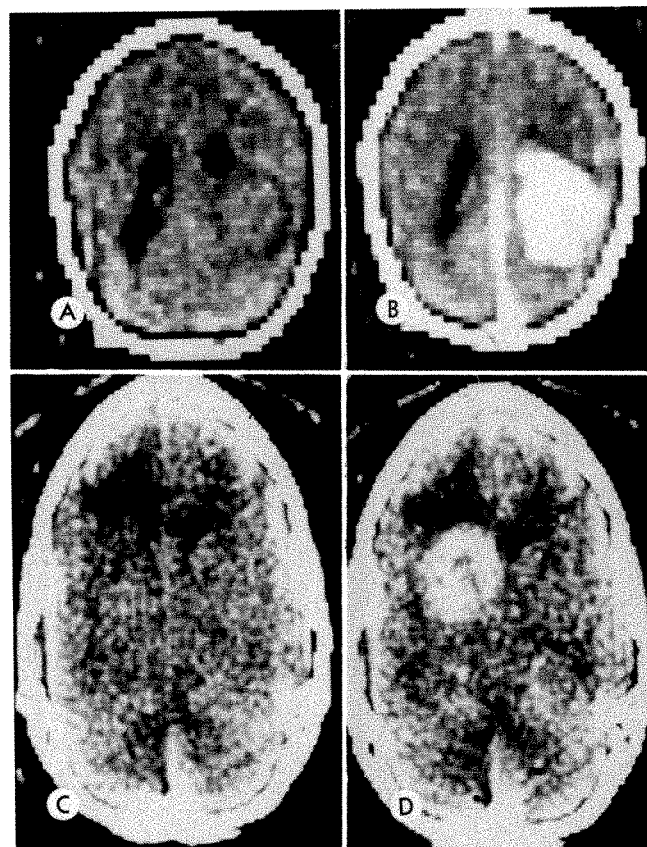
Cerebral hemisphere. A, Choroid plexus papilloma. Routine CT showing asymmetry of trigone and occipital horn of right lateral ventricle. B, Same patient with contrast enhancement clearly delineating large tumor in trigone. Also note enhancement of falx. C, Glioblastoma multiforme. Routine CT showing ill-defined area of decreased density in left frontal lobe. Left lateral ventricle not visualized. D, Same patient with contrast enhancement. Tumor in basal ganglia and thalamus extending to frontal lobe with edema (low density) anterior to tumor mass.
